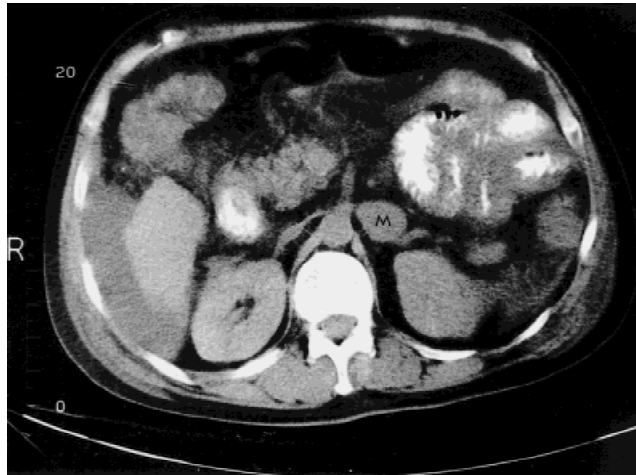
Transverse upper abdominal CT scan image shows a round 2.5-cm. homogeneous mass (M) in the left adrenal gland.
